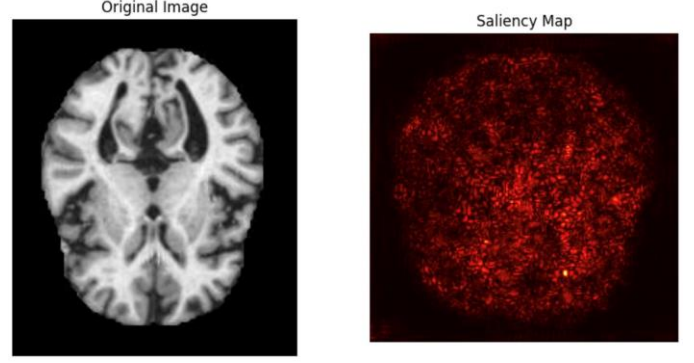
Original MRI scan of Control Case and the Saliency Map from the Pre-trained Model VGG16
